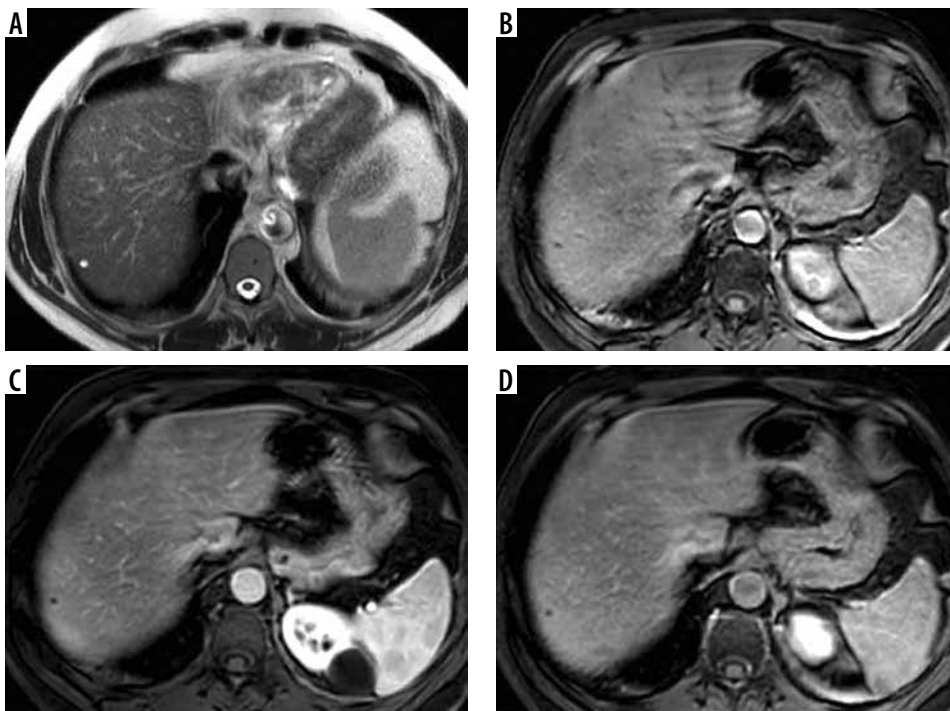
LR-1. Hepatic cyst. A) Axial T2-weighted image shows a high signal subcapsular hepatic lesion. B-D) No enhancement was seen in the arterial (B), portal venous (C), or delayed (D) phases
